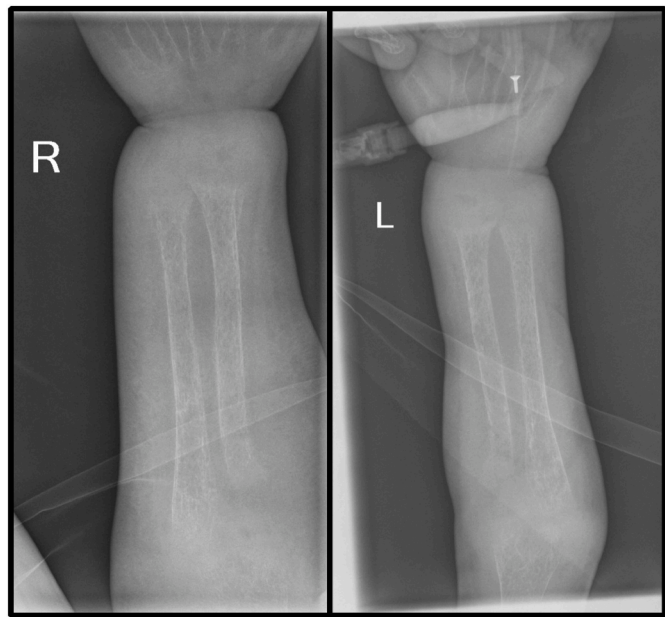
X-rays from bone scan demonstrating findings associated with rickets.
